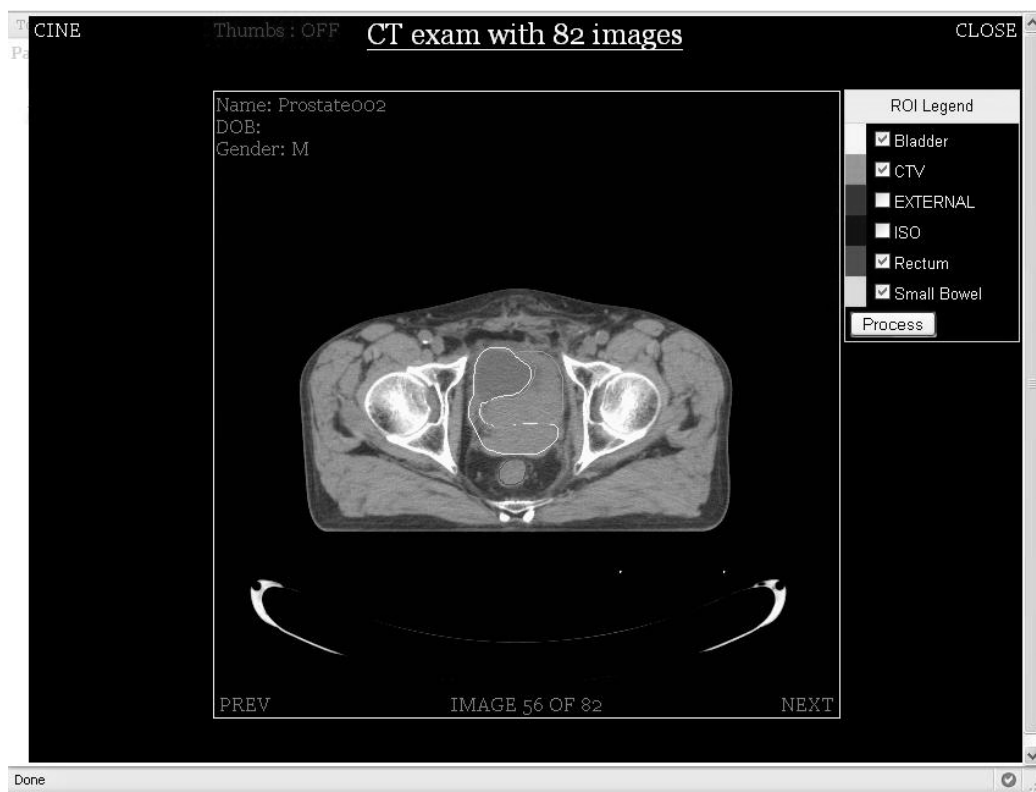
An screenshot of the ePR. The Graphical User Interface (GUI) allows the users to interact with the data stored on the ePR. In the screenshot shown above the users can dynamically select the ROI curves that they will like to display on top of the CT images. Both, the curves data points and the names of the ROIs are extracted from the RT objects that were sent to the ePR.
